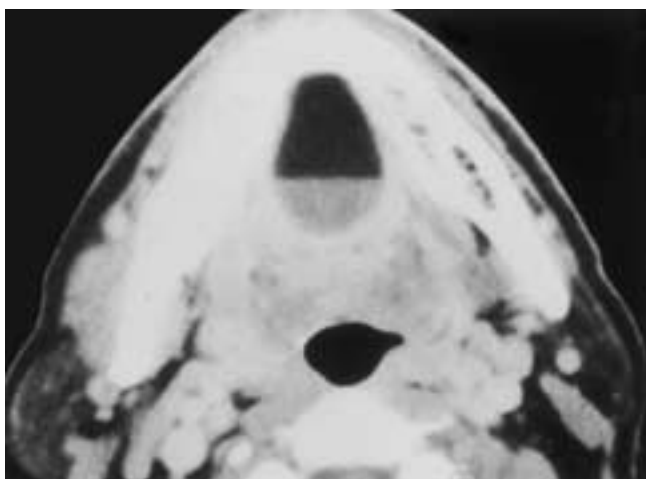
Dermoid cyst. Axial contrast-enhanced CT scan demonstrates a midline cystic lesion with a fat-fluid level and peripheral rim enhancement. The presence of fat is virtually pathognomonic for a true dermoid cyst.
